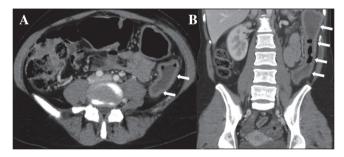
Transversal (A) and coronal reconstructed (B) CT scans, where a smooth, concentric thickening of the descending colonic wall may be seen (white arrows), with a minimal amount of free fluid within the pelvis (asterisk).
